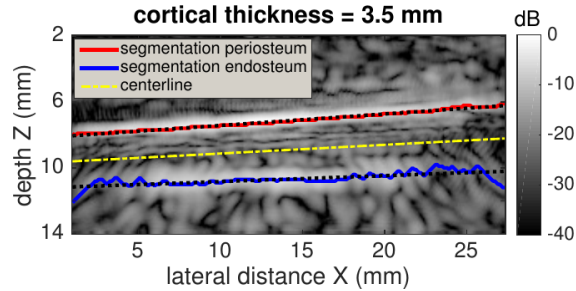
Reproduced from [73]. Ultrasound image of the cortical layer of a radius in vivo. Red and blue lines correspond to the periosteum and endosteum. Straight lines (dotted black line) approximate the interfaces. The cortical thickness, defined as the mean distance between these lines is found to be 3.5 mm for this acquisition and is in agreement with the thickness measured with HR-pQCT.
